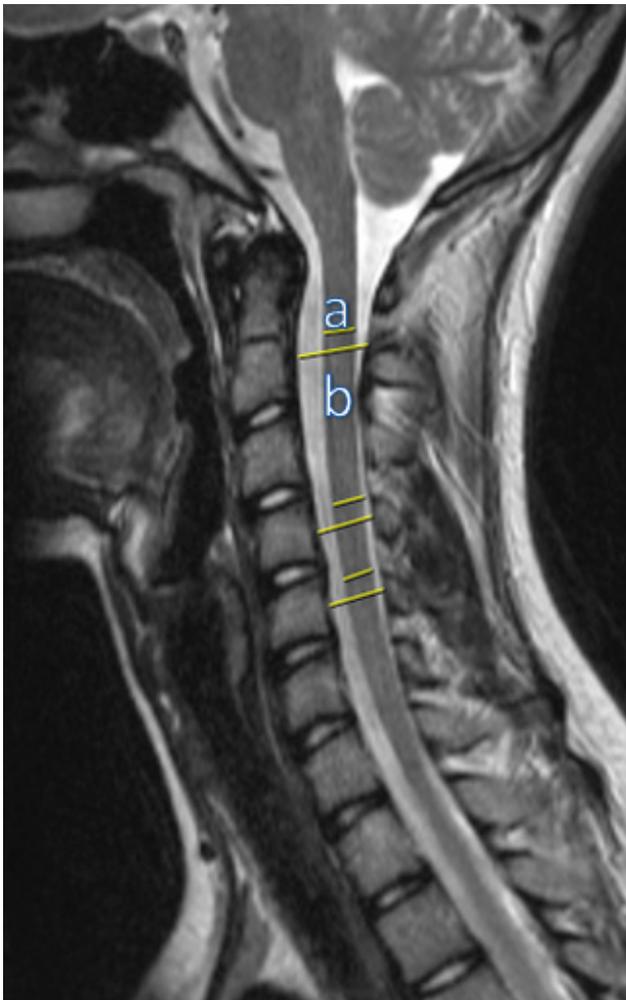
Sagittal section of T2-weighted MRI showing the measurements of the AP diameter of the spinal canal (a) and spinal cord (b). All the measurements are taken at the mid-vertebral levels
